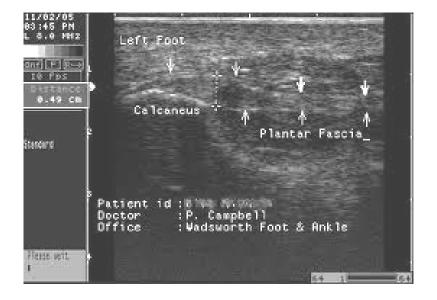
Ultrasound shows plantar fascitis
